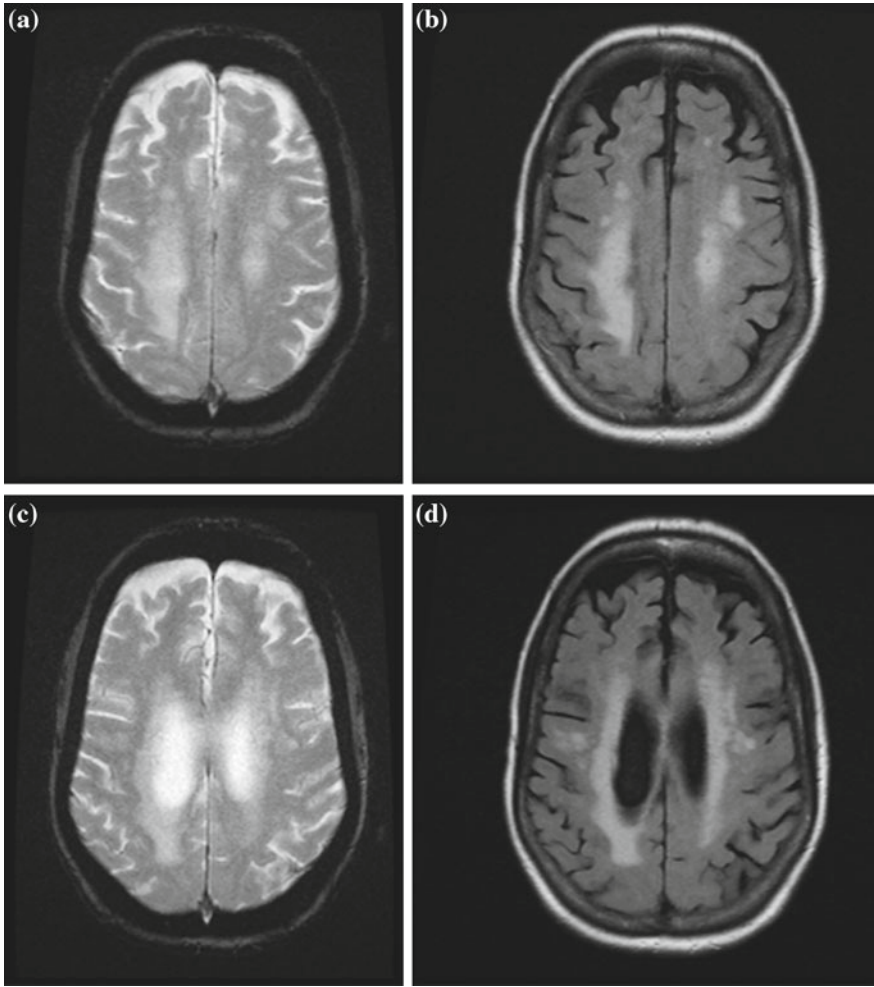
a T2-weighted. b FLAIR MRI. c T2-weighted MRI. d FLAIR MRI. Two T2 images (a, c) and the two corresponding FLAIR images (b, d)
